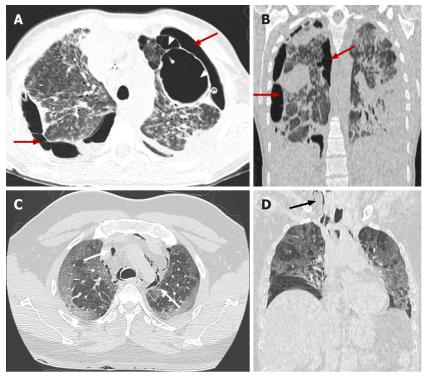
Coronavirus disease-2019 related acute respiratory distress syndrome, late stage. Axial (A) and coronal computed tomography (CT) (B) images demonstrate typical complications in mechanically ventilated patients with subpleural bullae formation (arrowheads) and bilateral pneumothorax (red arrows). Axial (C) and coronal (D) CT images in different patient showing spontaneous pneumomediastinum (white arrows), extending into the neck as subcutaneous emphysema (black arrow).
